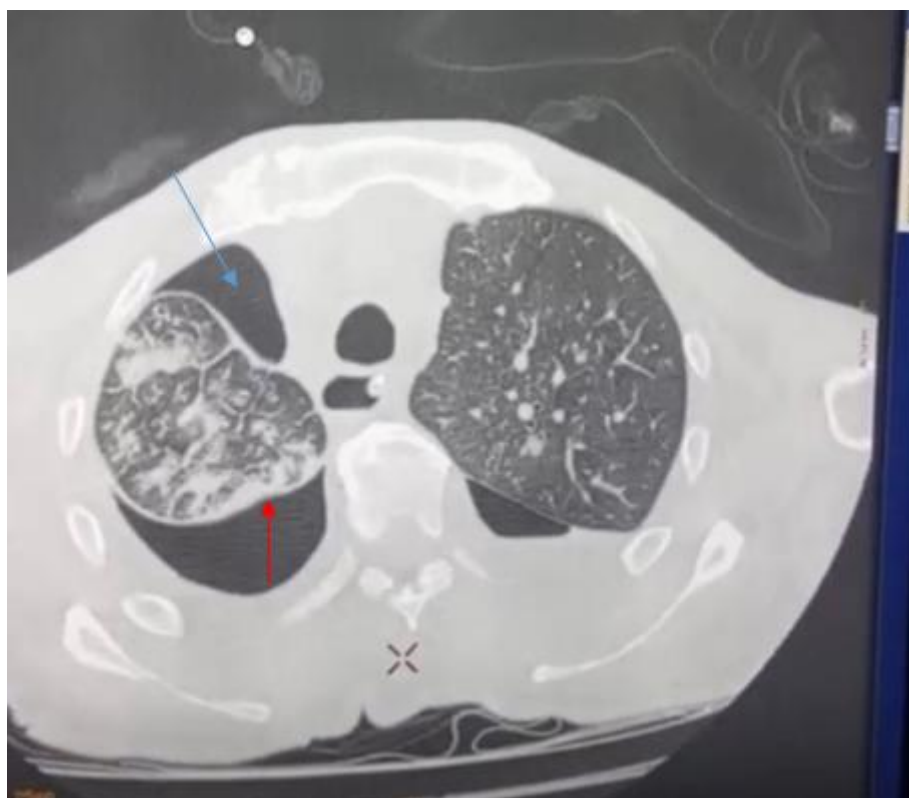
CT chest image demonstrating chronically collapsed, thickened right lung (red arrow) with persistent pneumothorax ex vacuo (blue arrow)
